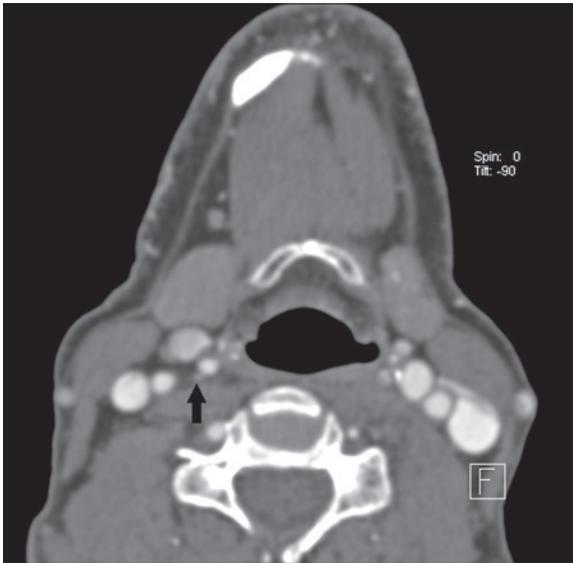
CTA examination of the carotid arteries. Axial projection. Modified protocol – beginning of acquisition: 90s from the moment of administering intravenous contrast agent.
